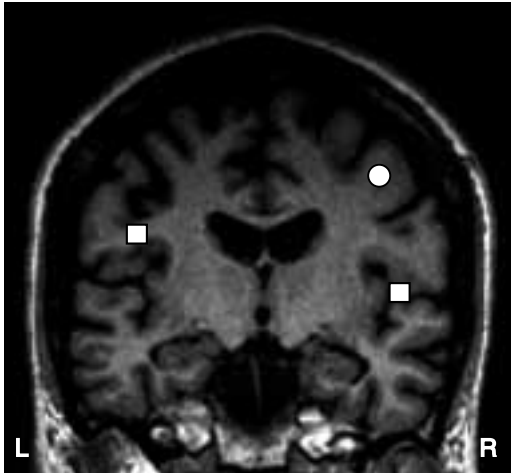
A T1-weighted coronal MRI of 40-year-old patient with NES. The circle denotes the location of P35m and squares the location of SII ECDs to LMN stimulation. L = left, R = right.
